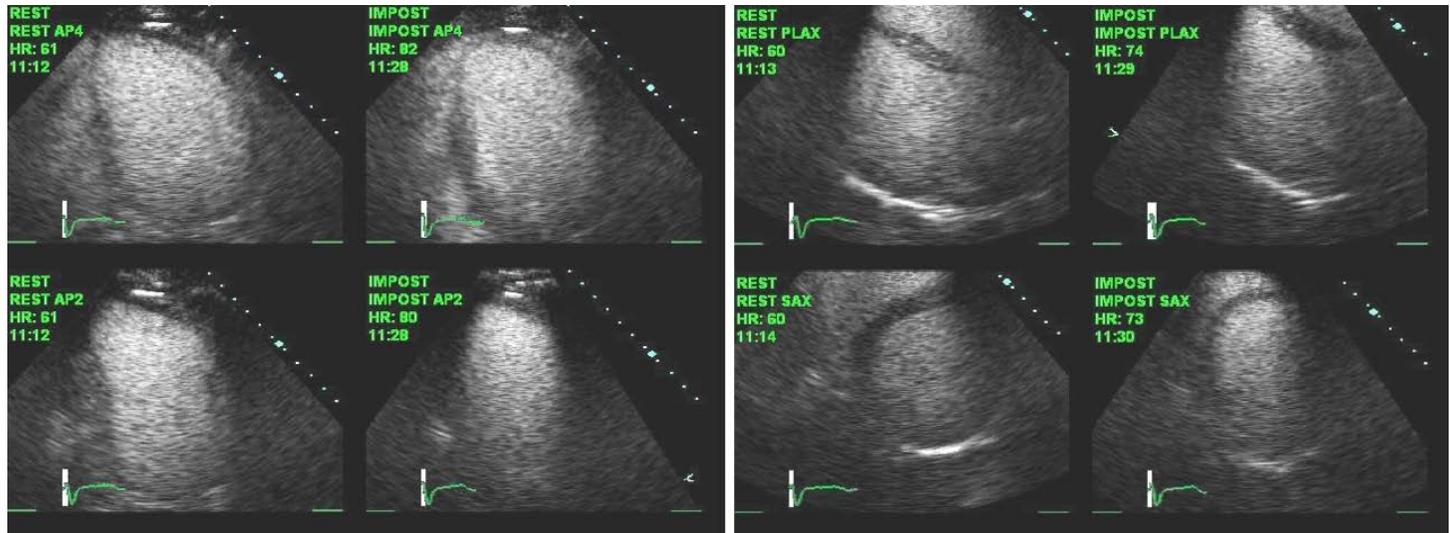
Treadmill contrast stress echo. Because the apex does not thicken with the rest of the walls post treadmill stress testing (IMPOST), further testing with computed tomography angiography (CTA) or invasive angiography is necessary. Baseline images are labeled REST.
